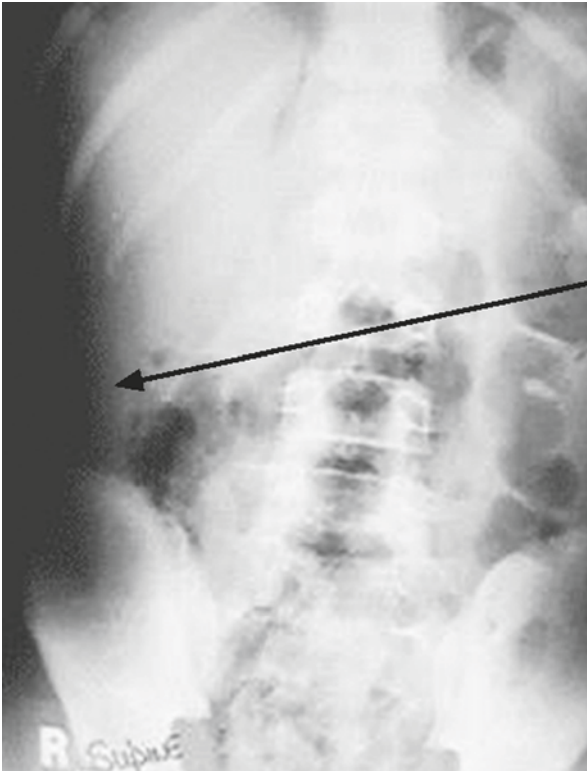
Abdominal X-ray: free retroperitoneal air (*arrow*)
